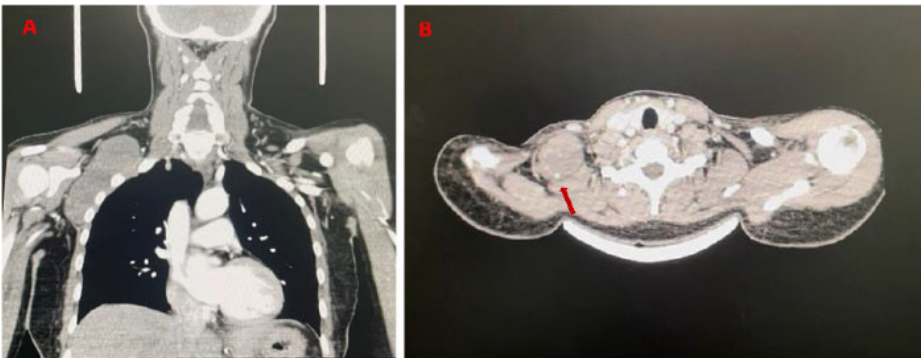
A) Coronal CT images show the mass extending and adhering to essential structures in the supraclavicular area. B) Opacities located on axial slices involving the soft tissue mass (red arrows).
